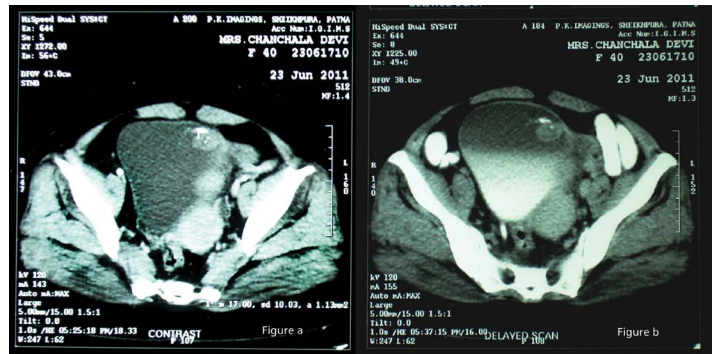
An axial CT scan of the urinary bladder revealing a mixed, attenuating dumbbell-shaped mass having intraluminal and extraluminal components at the left antero-superior region with calcification and punctuated fat.
